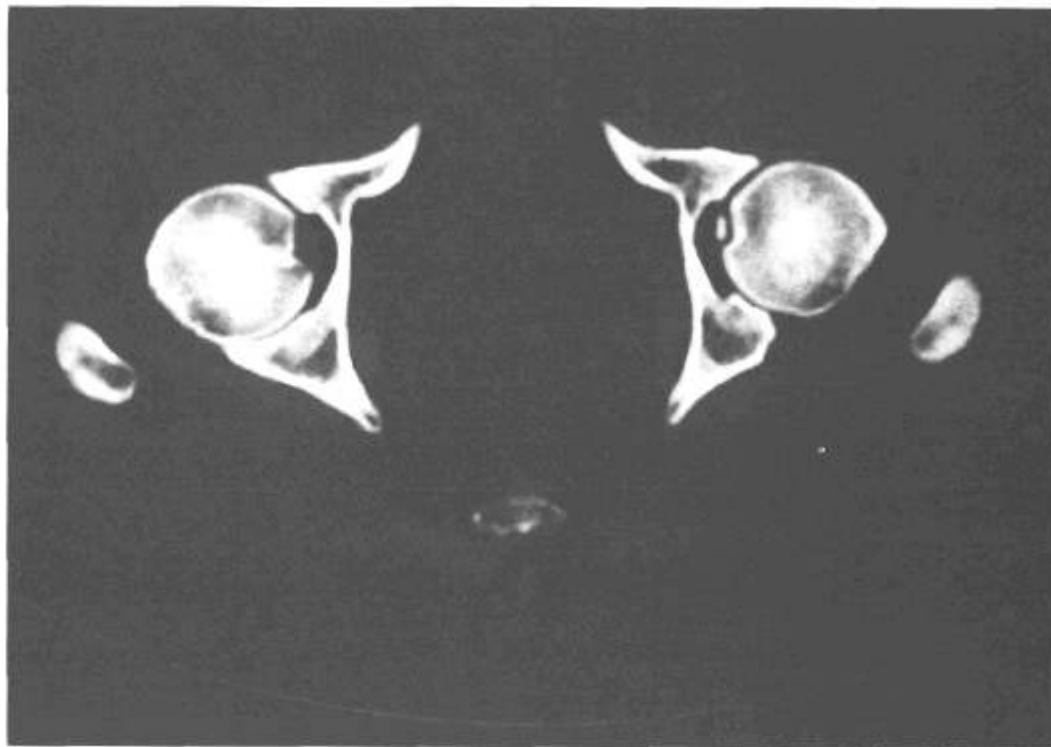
Acetabular fracture on a CT scan from which measurements are made.
